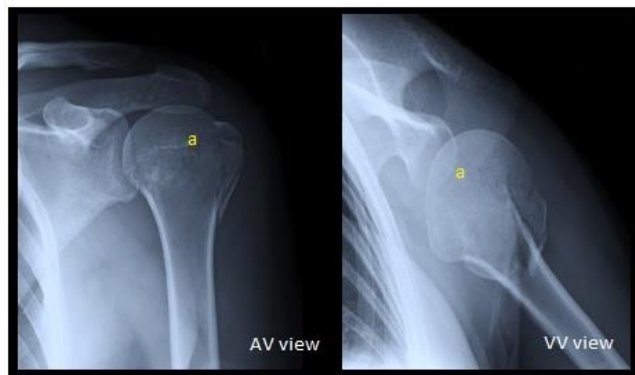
X-ray imaging showing improvement in PHF post 1 year (humeral head)
